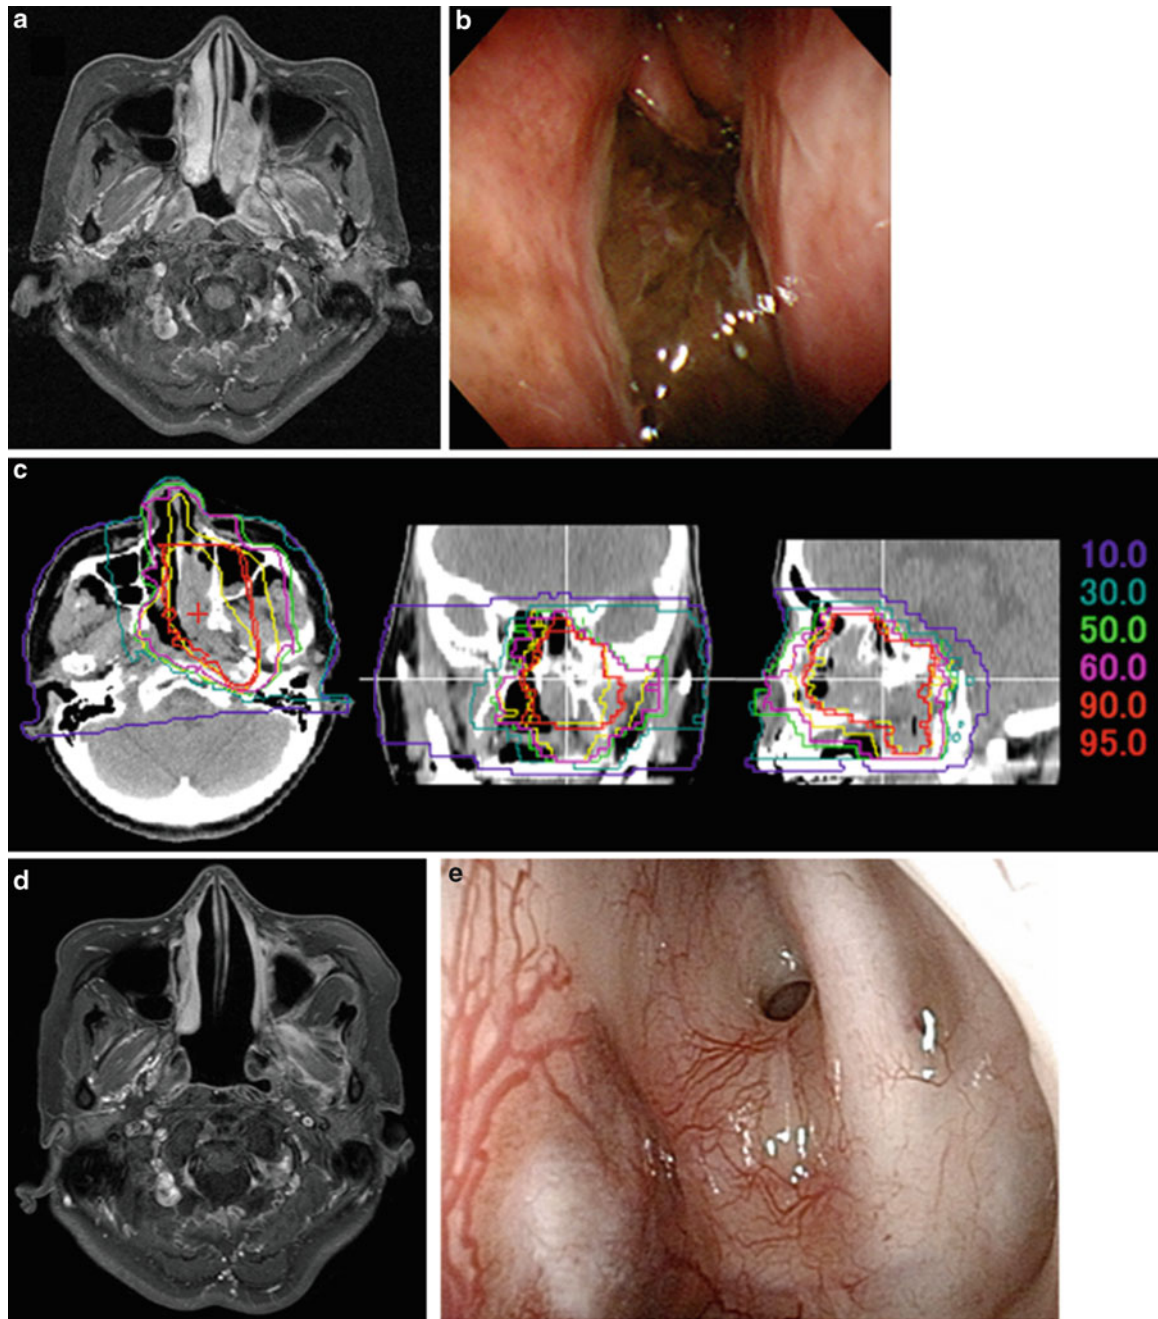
Left nasal MMM in a 66-year-old female patient. (a) Transverse contrast-enhanced fat-saturated T1-weighted MRI scan (Gadolinium [Gd]-MRI) before C-ion RT. (b) Endoscopic image before
